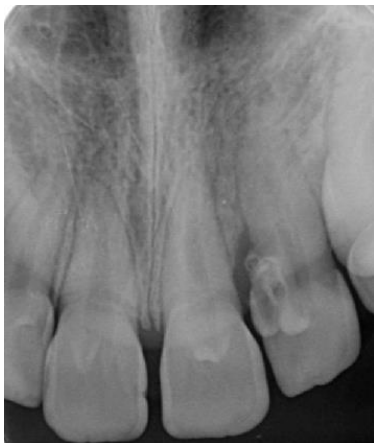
Periapical radiograph of maxillary lateral incisor demonstrating dens invaginatus with periradicular radiolucency.
